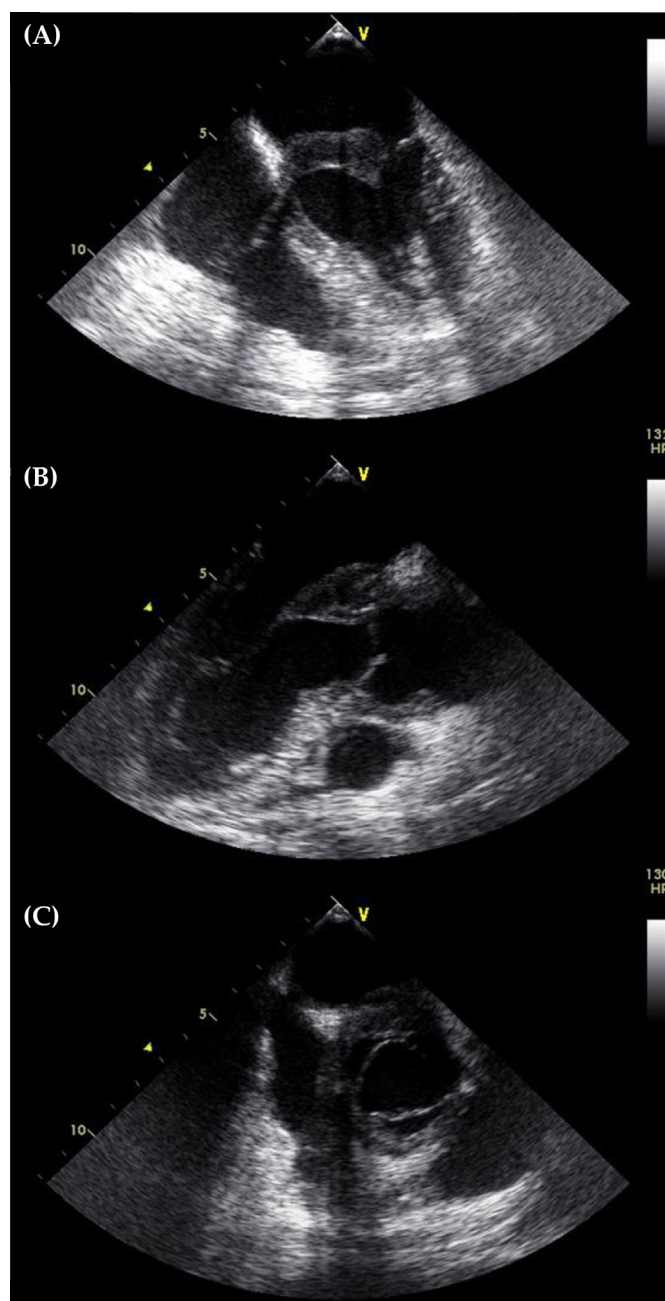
Anterior mitral valve thickening in transesophageal echocardiography (four-chamber view) (A), anterior mitral valve thickening and aortic root wall thickening in transesophageal echocardiography (aortic valve long-axis view) (B), and aortic root wall thickening in transesophageal echocardiography (aortic valve short-axis view) (C). Adapted from Davarband et al. [165].
